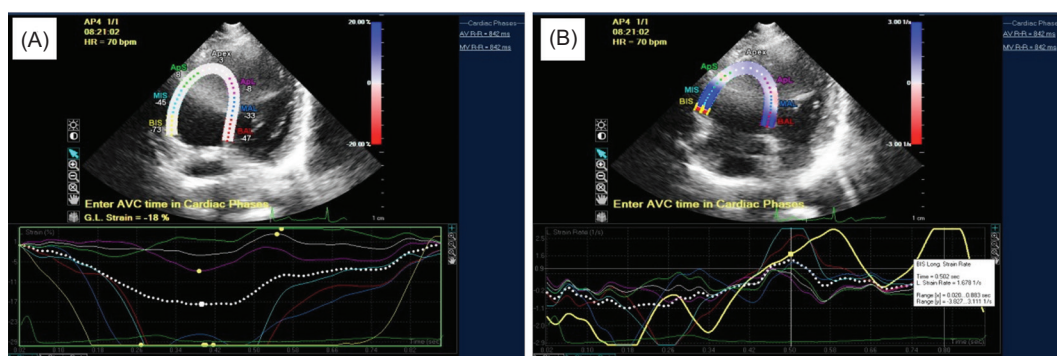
Right ventricle peak systolic strain (A) and strain rate (B) measurements in 2D-STE. RV strain reflects the degree of longitudinal myocardial deformation during systole, whereas strain rate reflects the speed of this deformation. These parameters allow quantitative assessment of RV systolic mechanics and may help detect subtle myocardial dysfunction before abnormalities become evident on conventional echocardiographic indices.
